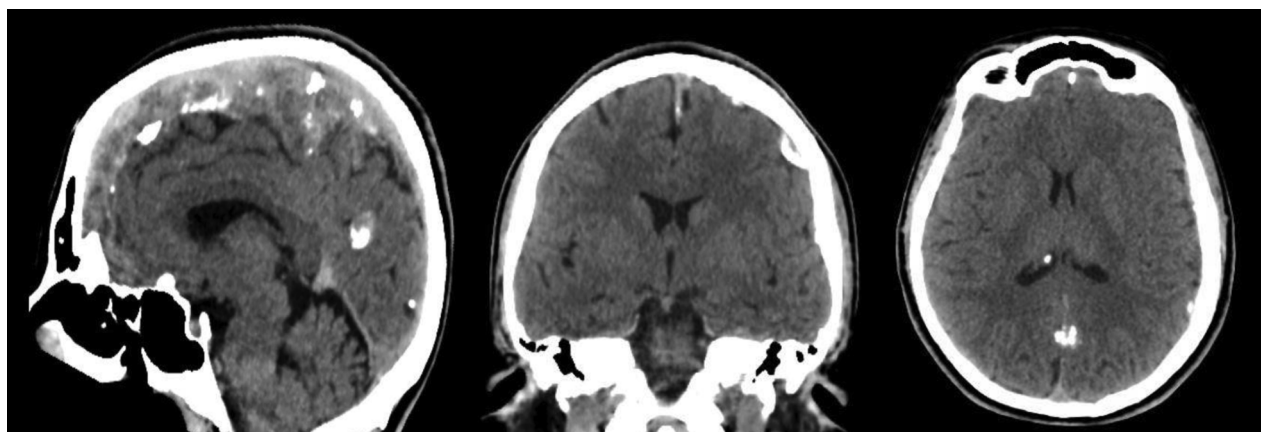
The basal CT scan showed several solid, well-defined, and extra-axial masses involving the mid falx cerebri, which are spontaneously hyperdense, with some minor peripheral calcifications foci.
